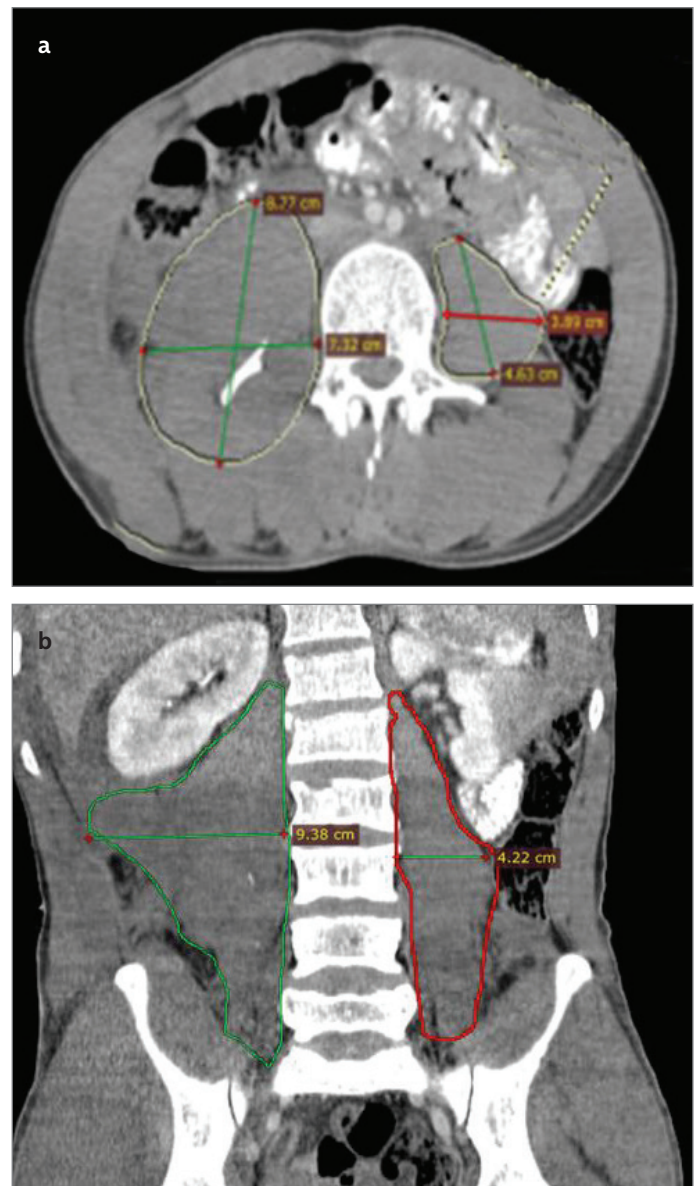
a, b. (a) CT scan image immediately after trauma: L4 right transverse process dislocation fracture with hematoma of the right ilio-psoas muscle, muscle volume increased (right ilio-psoas muscle; 8.77 cm X 7.32 cm, left ilio-psoas muscle 4.63 cm X 3.93 cm) (b) Abdomen CT image immediately after trauma: Increased ilio-psoas muscle volume was noted
